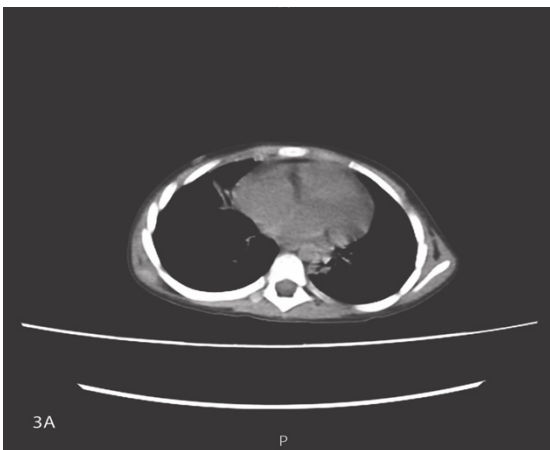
Mediastinal (A) and lung (B) window of the patient's chest computed tomography scan. This indicated moderate pericardial effusion and consolidation in the left lower lobe.
